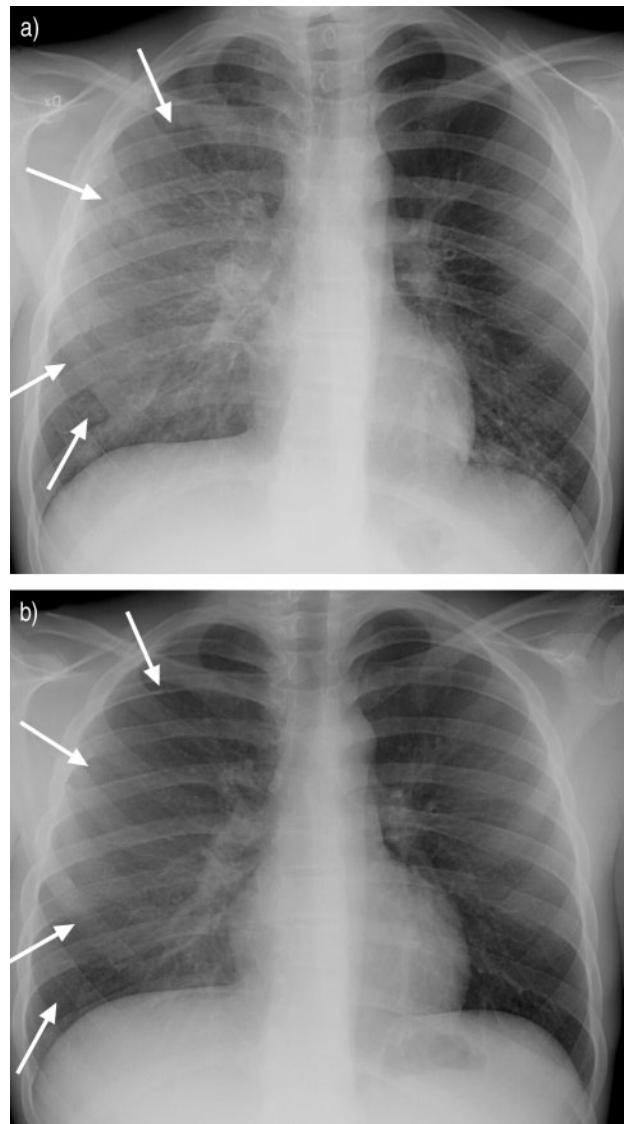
Extended right-sided consolidation (arrows) in a 16-yr-old male (case number 4) with fever and productive cough. Radiography was performed a) 11 days and b) 2 months after onset of disease.
